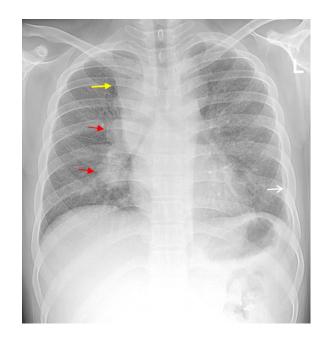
Conventional chest radiograph, PA.
